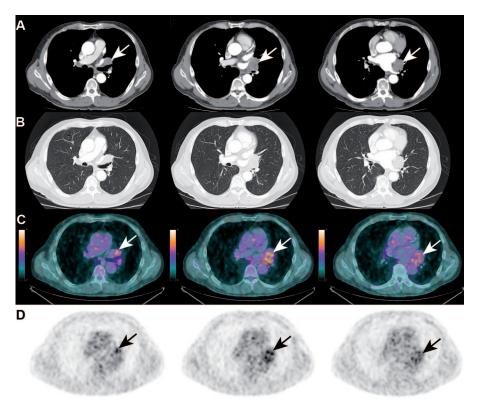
A nonsmoker 75-year-old man without any symptoms treated for atrial fibrillation and hypertension, was referred to our hospital after the incidental finding of a left pulmonary hilar mass. Transaxial-enhanced CT images in mediastinum (A) and lung (B) windows showed a solid mass (arrow) encompassing the left upper bronchus without the sign of vascular or mediastinal invasion, but with a compression of the left upper pulmonary vein. The lesion showed area of necrosis without calcifications. Flexible bronchoscopy showed a mucosal inflammation at the level of left upper bronchus with discrete extrinsic compression. Different biopsies obtained at bronchoscopy under endobronchial ultrasound (EBUS) guidance could not achieve
